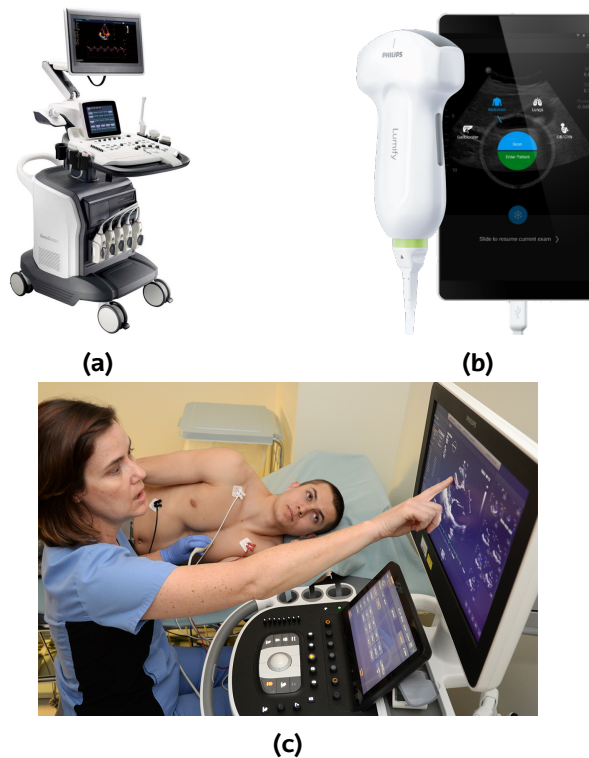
Example of a) typical in-hospital echocardiograph (image extracted from [[Son](#)]), b) an echocardiograph intended for out-of-hospital situations [[NV](#)]. c) Example of use [[Dip20](#)].
